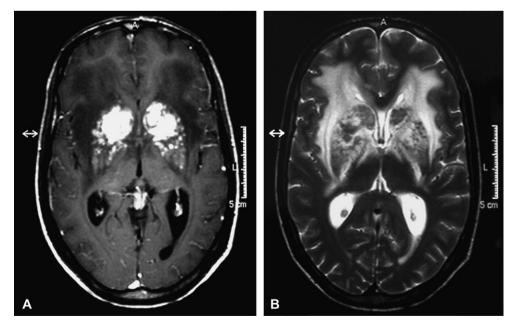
MRI scans. (A) Distinct symmetric hyperintense lesions in the basal ganglia on the T1 weighted MRI scan. (B) Diffuse contrast medium enhancement in the basal ganglia and perifocal edema on the T2 weighted MRI scan.
